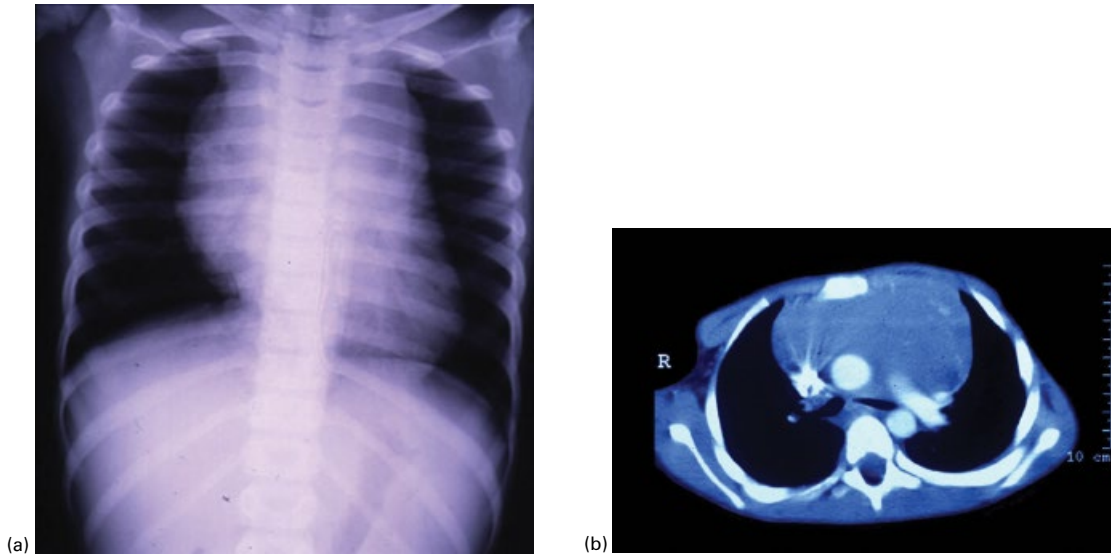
Chest radiograph (a) and computed tomography scan (b) of a child with T-ALL showing massive thymic enlargement.
